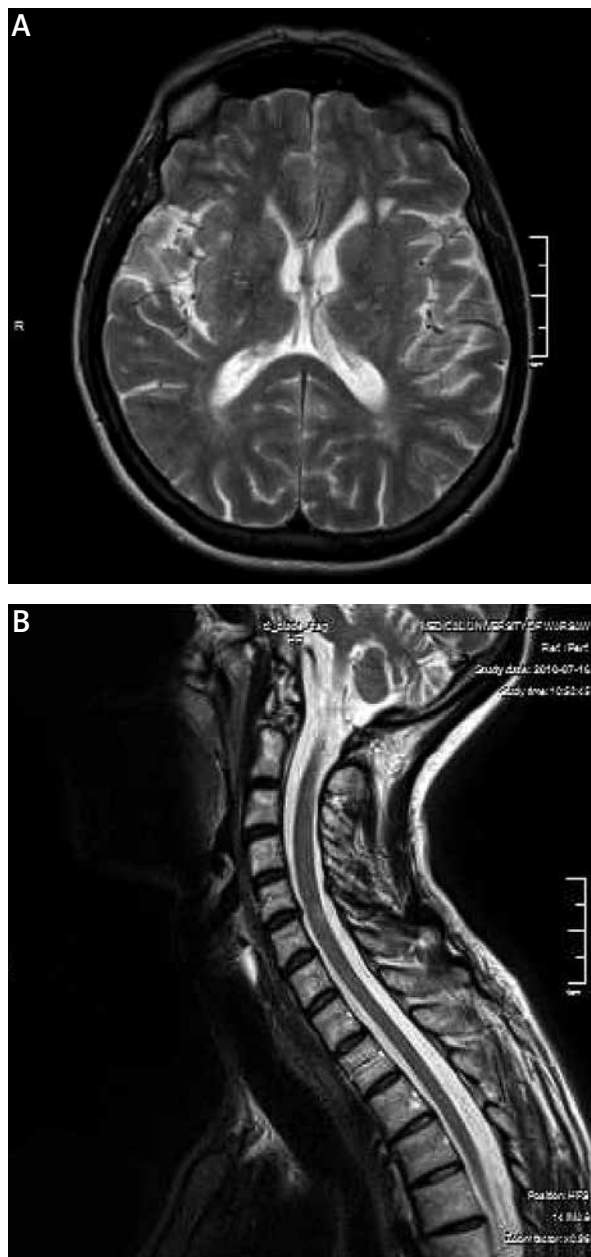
Case 7. A) Axial T2 MR image shows multiple foci of hyperintense signal in both thalami and periventricular/subcortical white matter; B) Cervical MRI revealed few intramedullary demyelinating plaques and discopathy at the C4/C5 level.
